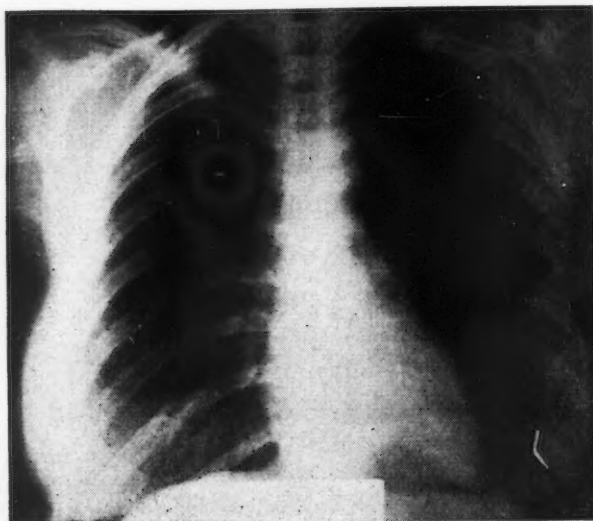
Roentgenogram taken under the same conditions as in Fig. 1 with no significant evidence of increased radiological lung volume on the left. Note particularly the marked movement of the right side of the diaphragm.
